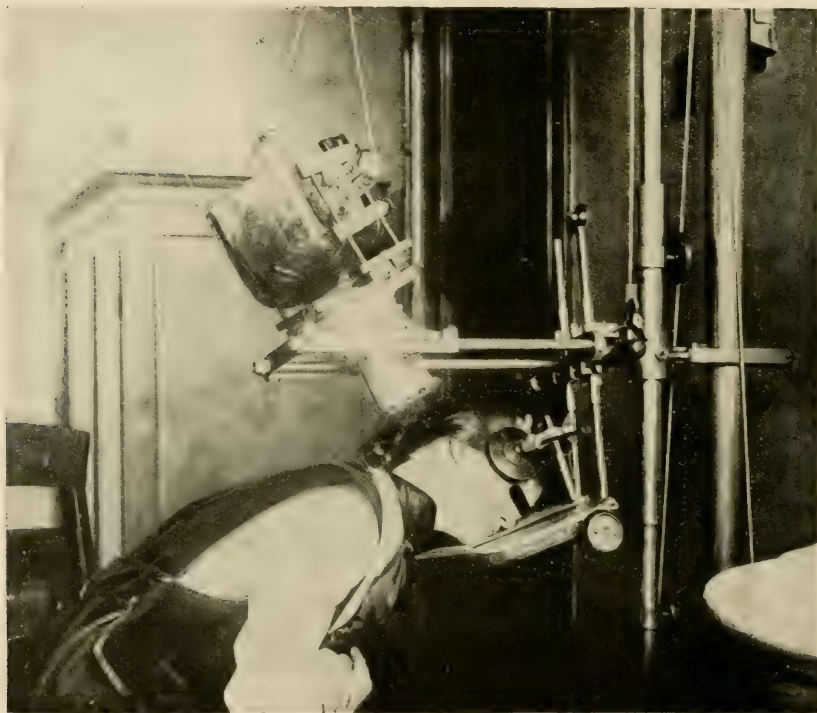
Tube stand with attachment for making extra-oral radiographs. (Photograph by Dr Eisen.)
